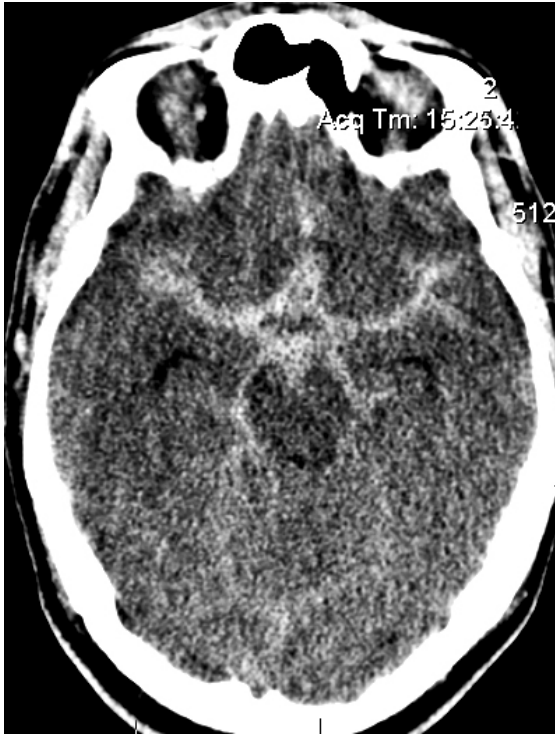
CT scan of the brain showing subarachnoid hemorrhage
